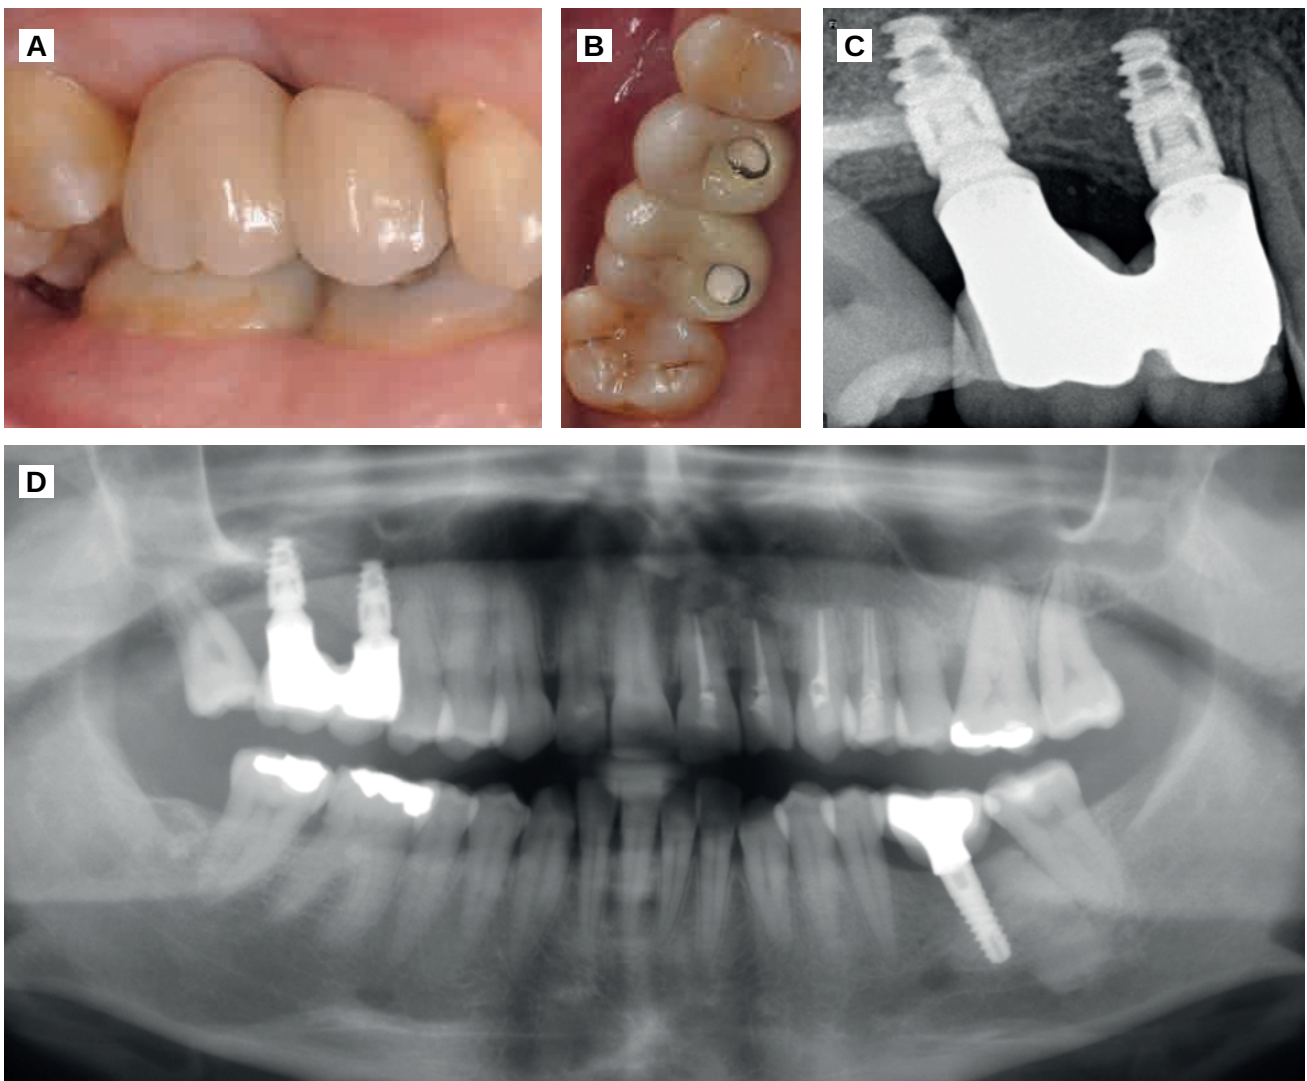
Images at six months post-loading. A. Lateral view of the implant-supported crowns. B. Occlusal view of the implant-supported crowns. C. Periapical radiograph. D. Panoramic radiograph.
